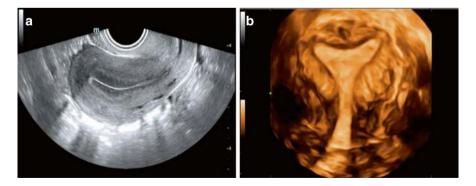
(a) Intracavitary 2D ultrasound image showing the midsagittal plane of the uterus. (b) Intracavitary volume ultrasound image displaying a 3D view of the uterus in the coronal plane
